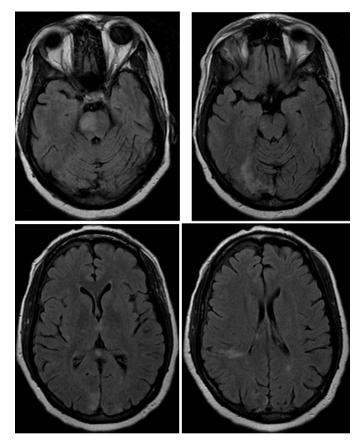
MRI brain (axial FLAIR slices) revealing multiple areas of hyperintensity.
